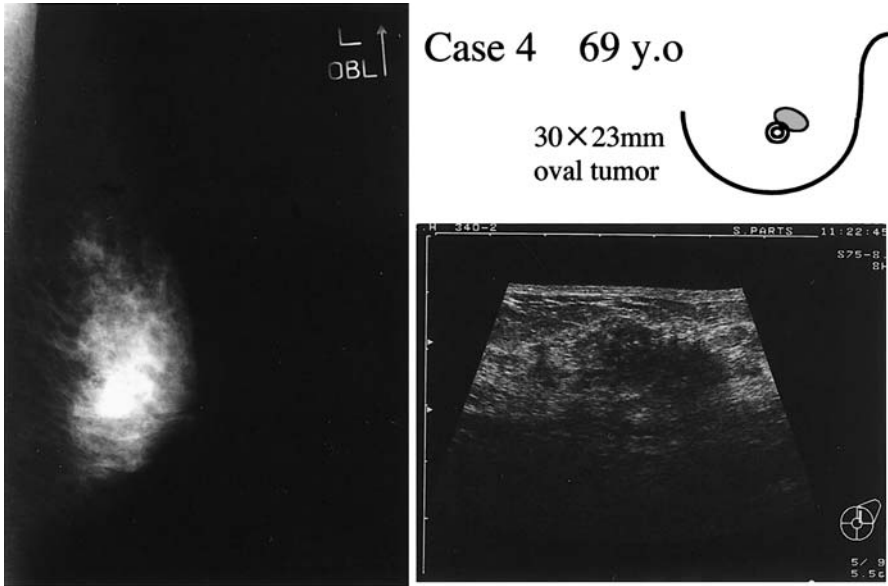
High-density mass in MMG; oval tumor by ultrasonography. This case was different from the others
